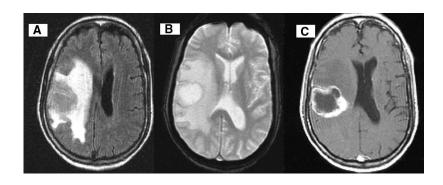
Axial (*A*) FLAIR, (*B*) FLASH 2d, (*C*) postcontrast T1W. A 64-year-old neurologically asymptomatic man with stage IV NSCLC of the left lung with solitary hemorrhagic and necrotic metastasis in the right parietal lobe measuring 4.4 cm.
